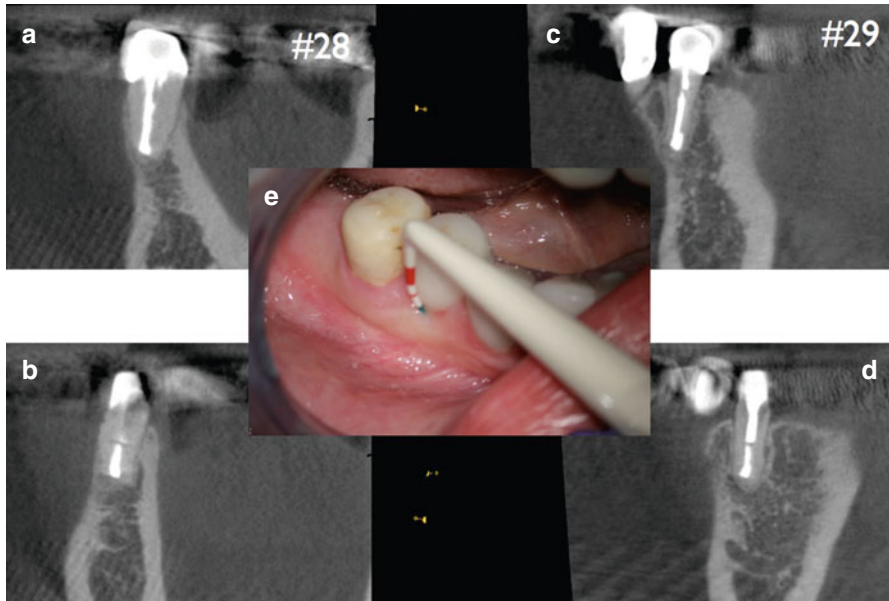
Continuation of case presented in Fig. 6.22: 18-month CBCT coronal and sagittal views demonstrating complete remodeling of the defect and the buccal plates (a–d). Clinical picture of 18-month recall demonstrating normal color, texture, and periodontal attachment (e)
